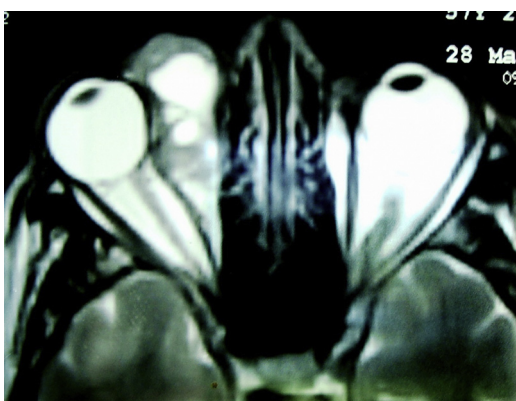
RMI: axial T2-weighted image showing intraorbital high signal mass. No evident signs of muscle or ocular invasion.
